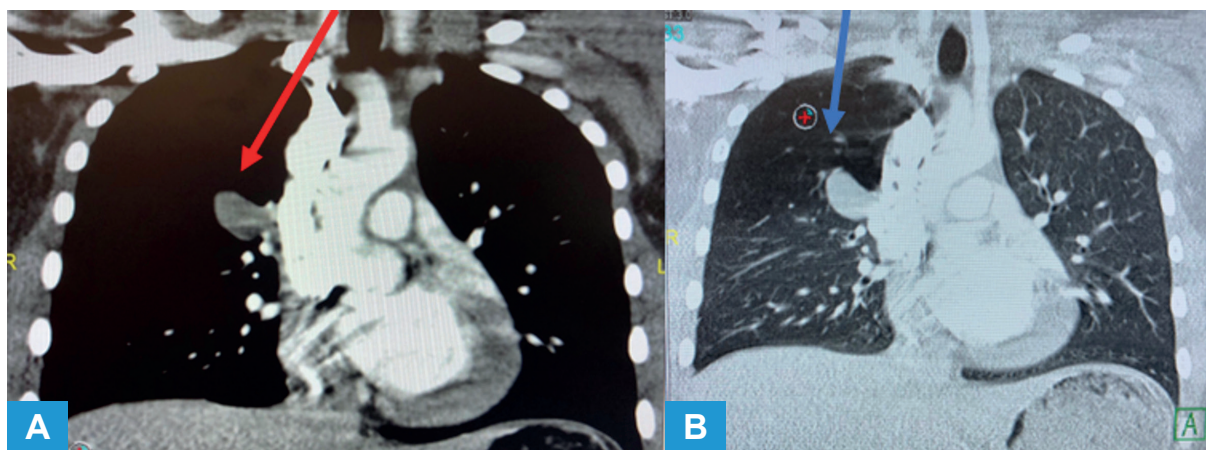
9-year-old girl: chest CT scans demonstrate RUL bronchial atresia with mucocoele and hypodense area visible in the RUL area. Lobectomy was done due to recurrent infections.
